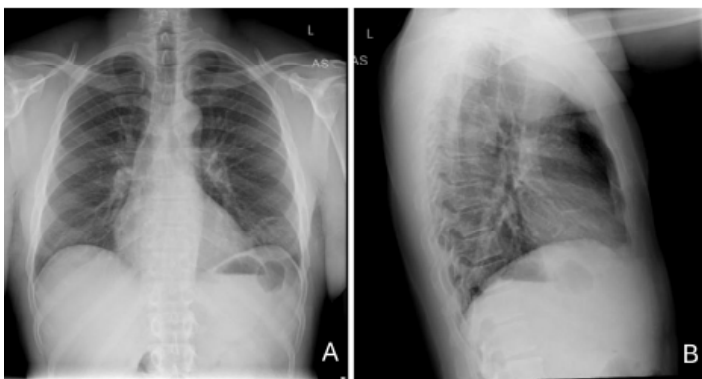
Posterior-anterior (A) and lateral (B) chest radiographs of a 51-year-old male who presented with back pain, lower extremity numbness, and a progressive purpuric rash.
